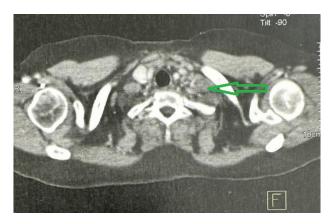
Axial contrast-enhanced CT scan shows a 3 cm left internal supraclavicular necrotic adenopathy (green arrow).
